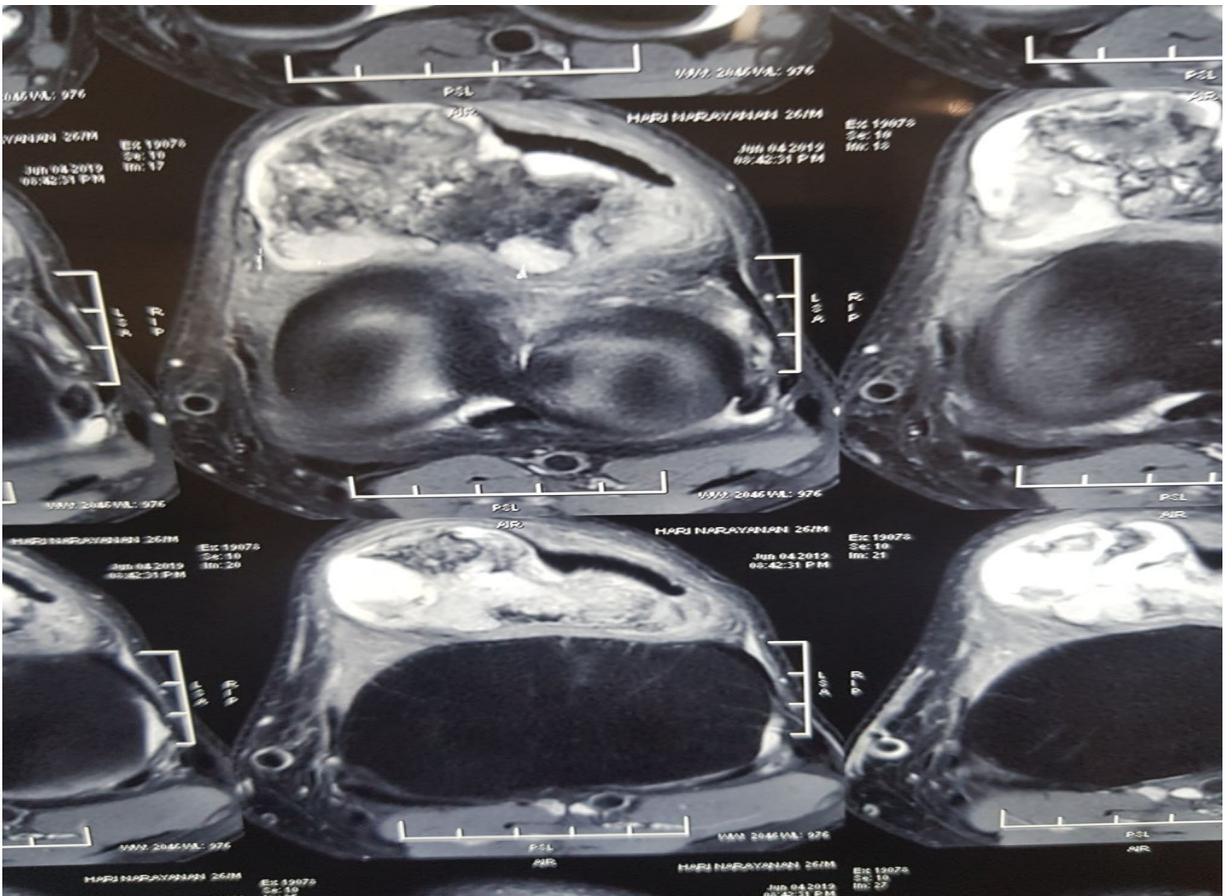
Axial T2 weighted MRI sequence showing a densely calcified lesion measuring 5.9x 4.0x 6.2 cm, in the Hoffa's fat pad with peripheral soft tissue component. Articular cartilage did not reveal any evidence of erosion
